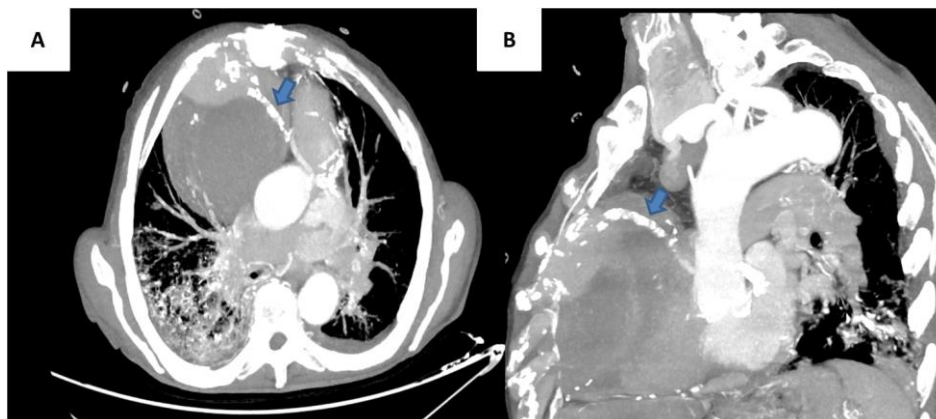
Giant coronary artery aneurysm and right coronary artery in axial MIP image (A) and sagittal MIP image (B) on contrast-enhanced CT angiography
